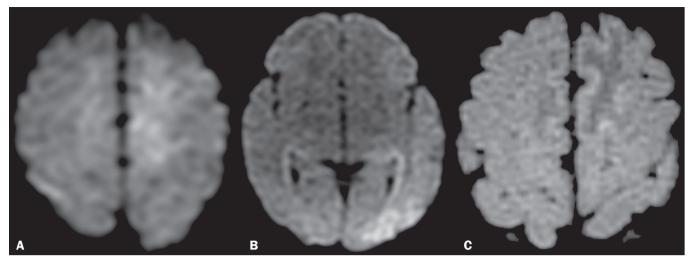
Diffusion-weighted MRI scans of the brain of a newborn, born to a woman with lupus, who presented a convulsive episode, showing areas of restricted diffusion in the upper left frontal gyrus and left temporo-occipital region (A,B), which showed a differential with changes related to status epilepticus and ischemic events related to neonatal lupus. A blood test revealed anti-Ro positivity. An MRI scan obtained one week later showed a zone of signal intensity change in the parasagittal frontoparietal region, consistent with ischemic lesions in the subacute phase (C).
